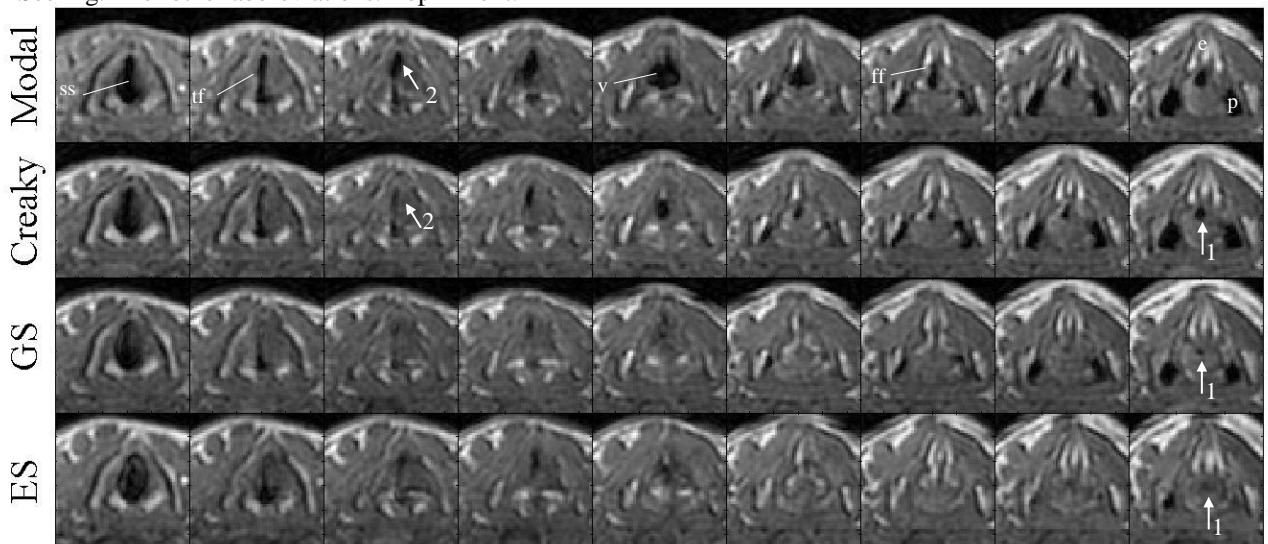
Axial MRI sections: modal voice, creaky voice, [?] (GS), and [?] (ES); all in [i]-context. p = piriform fossa. See Fig. 1 for other abbreviations. Top = front.
